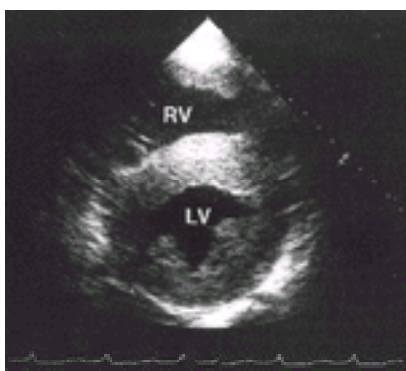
Echocardiographic demonstration of concentric thickening of the left ventricular (LV) wall from amyloid. RV, right ventricle. [From Gertz MA, Kyle RA. Amyloidosis (AL). In: Wiernik PH, Canellos GP, Kyle RA, et al., eds. Neoplastic diseases of the blood, 4th ed. New York: Cambridge University Press, 2003, with permission.]
